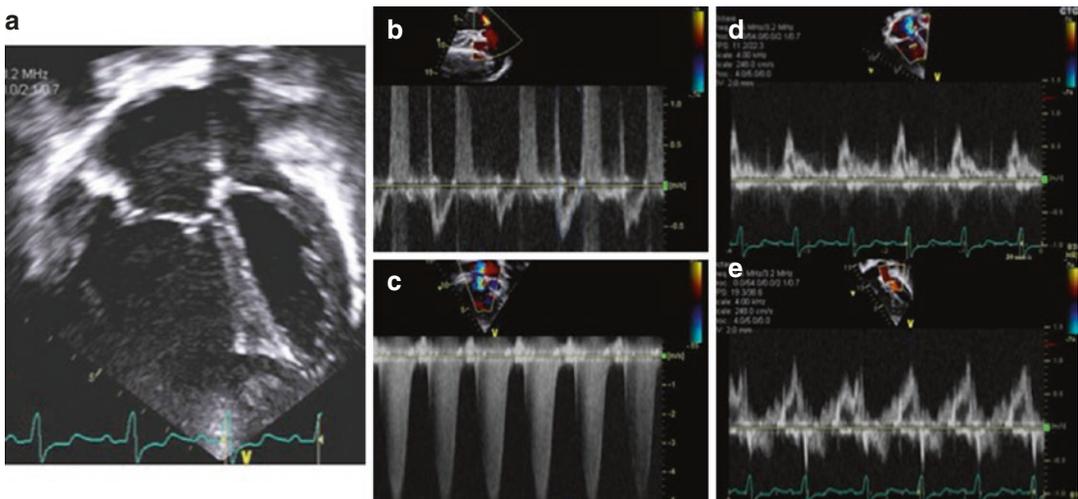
Child with severe idiopathic pulmonary hypertension. Panel (a) depicts an apical 4-chamber view showing a markedly dilated right ventricle which compresses the left ventricle in systole and diastole. Panel (b) depicts Doppler in the pulmonary artery. Right ventricular ejection is short in duration and reducing volume due to severely increased pulmonary vascular resistance (Panel b). However, right ventricular contraction and systole, is actually prolonged as seen by the duration of tricuspid regurgitation (Panel c). Thus, Doppler of the tricuspid regurgitation jet is useful not only to measure right ventricular systolic pressure, but also the duration of systole (duration of the tricuspid regurgitation) and diastole (the duration of the interval between tricuspid regurgitation
